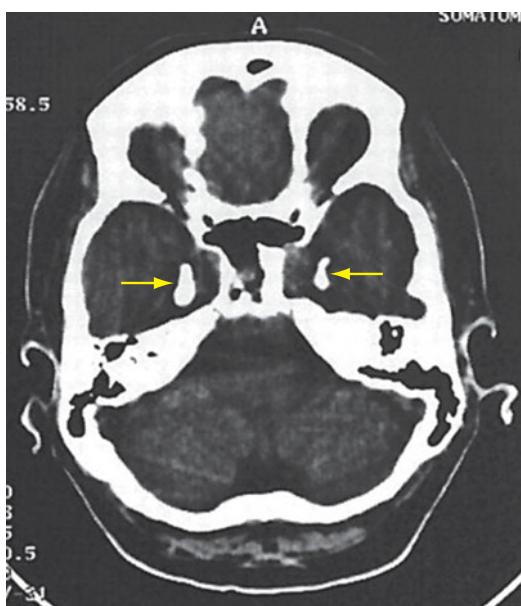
Bilateral lesions of the amygdala (yellow arrows) can be seen in this computed tomography or CT scan of a patient with Urbach-Wiethe disease.
